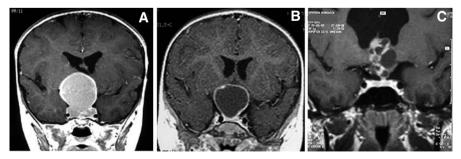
Relationship of the craniopharyngiomas to the sella on coronal MRI scans. A Intrasellar and suprasellar, B suprasellar extraventricular, C intraventricular and extraventricular
